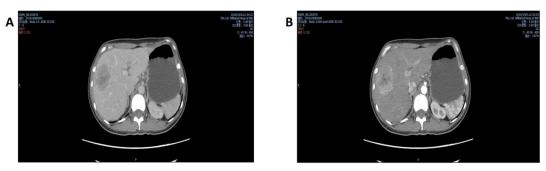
CT A: The arterial phase, B: The portal phase
